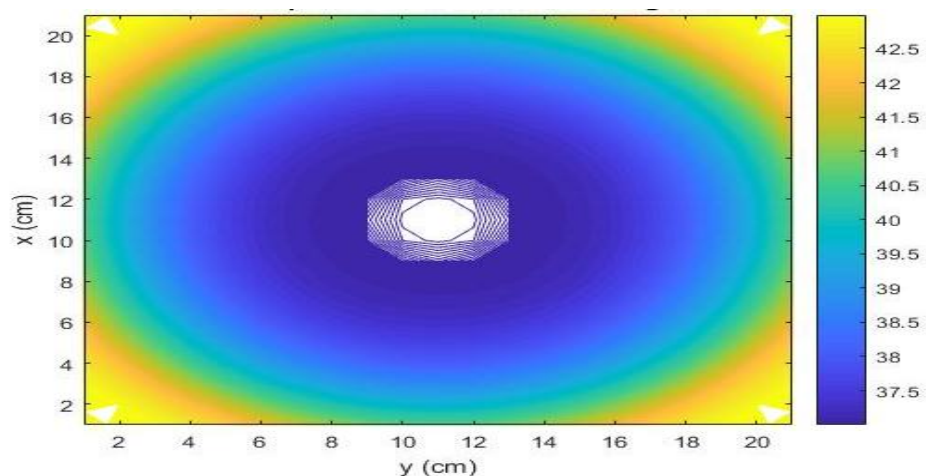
2-D Head Temperature during Brain MRI.
